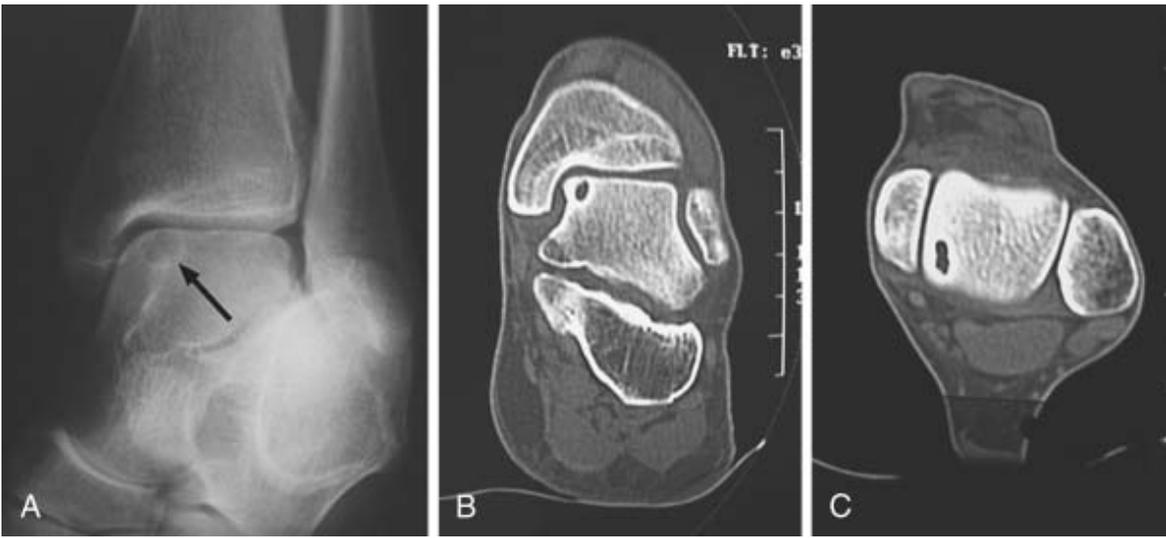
A, Posteromedial osteochondral lesion of the talus (arrow). B, Coronal plane CT image. C, Axial plane CT image. (From Richardson DR: *Ankle injuries*. In Canale ST, Beaty JH [eds]: *Campbell's Operative Orthopaedics*, 11th ed. Philadelphia, Elsevier, 2008.)
